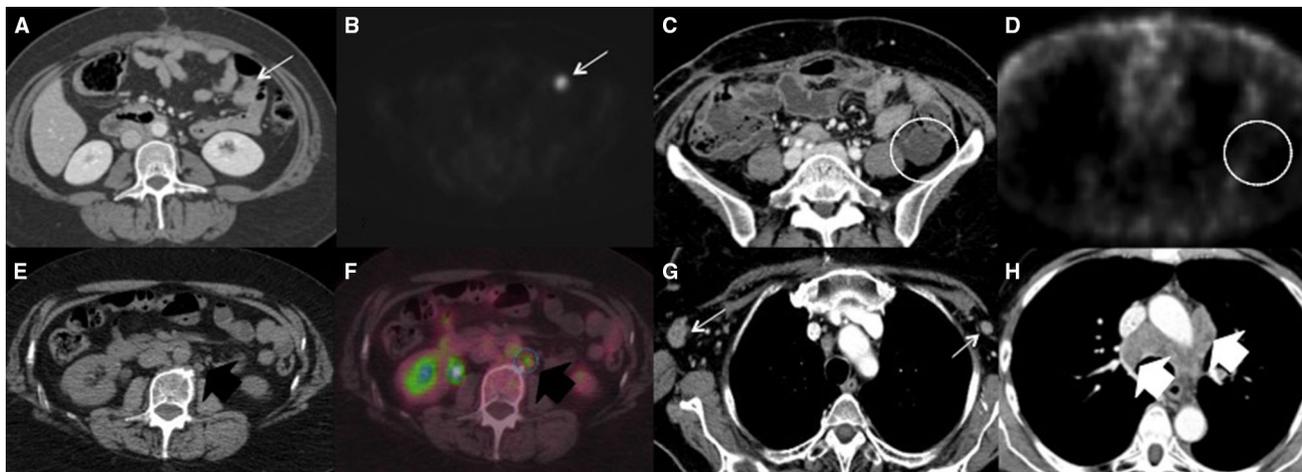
In a 63 years old patient who underwent primary surgery for serous ovarian cancer, with raised CA-125 blood level but negative CT scan (A), PET/CT showed a small nodular area of FDG uptake on the surface of a bowel serosa (B; white arrow), which was not detected on the CT scan because it was misinterpreted as a bowel loop (A; white arrow). C, D: In a 48 years old patient with recurrent mucinous ovarian cancer, an axial CT image (C) shows a
